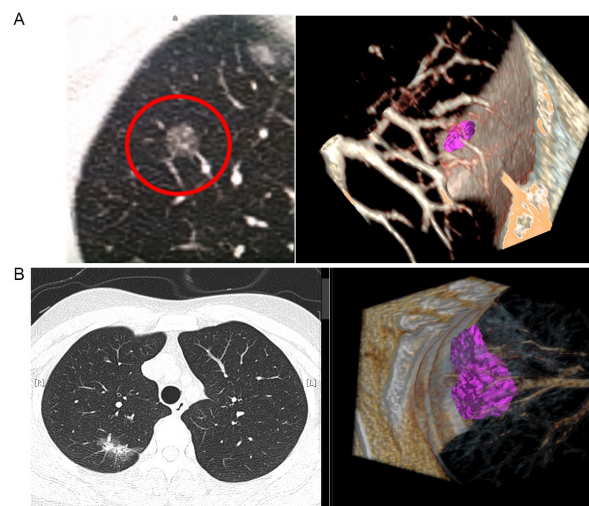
(A) Axial computed tomography (CT) images show pure nonsolid nodule of the right lower lobe with microvascular sign in the pure ground glass opacity. Microinvasive adenocarcinoma was found on pathologic examination. (B) Axial CT images show a pure nonsolid nodule of the right lower lobe, with microvascular sign in the part-solid nodules, and vascular convergence sign surround the nodules. Invasive adenocarcinoma was found on pathologic examination.
